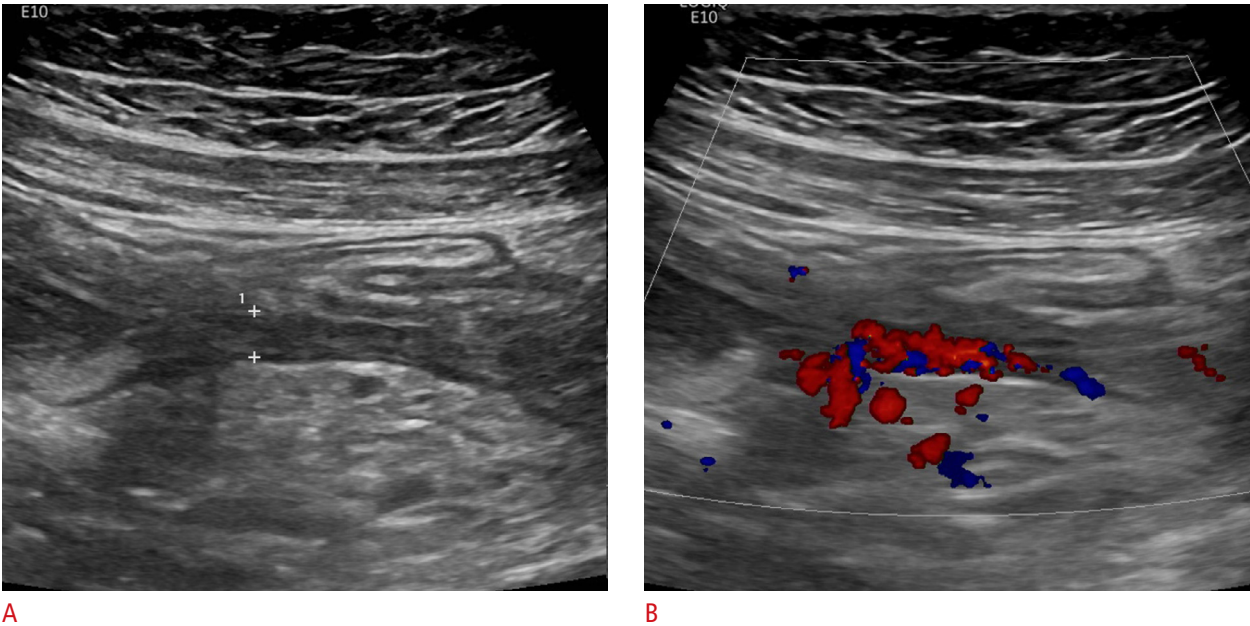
Quantitative scoring of disease activity using intestinal ultrasonography parameters. Bowel wall thickening (4.5 mm) with loss of bowel wall stratification (A) and increased Doppler signal (modified Limberg score 3, B) indicate active inflammation. The Simple Ultrasound Score for Crohn’s Disease score is 3 (bowel wall thickness score 1+Crohn disease score 2), exceeding the cut-off of 1. The International Bowel Ultrasound Segmental Activity Score is 66 (4×4.5+15×1+7×3+4×3), exceeding the cut-off of 48.7. The Bowel Ultrasound Score is 5.025 (0.75×4.5+1.65×1), exceeding the cut-off of 3.52—all indicating active inflammation.
